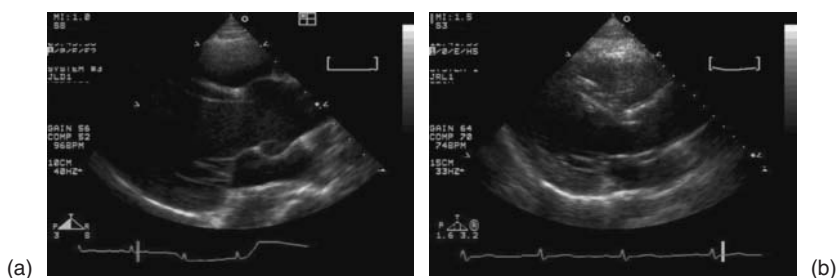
Dilated aorta by echocardiography. (a) Dilated sinuses in a patient with Marfan syndrome. (b) Effacement of the sinotubular junction and dilation of the proximal ascending aorta in a patient with a BAV.
